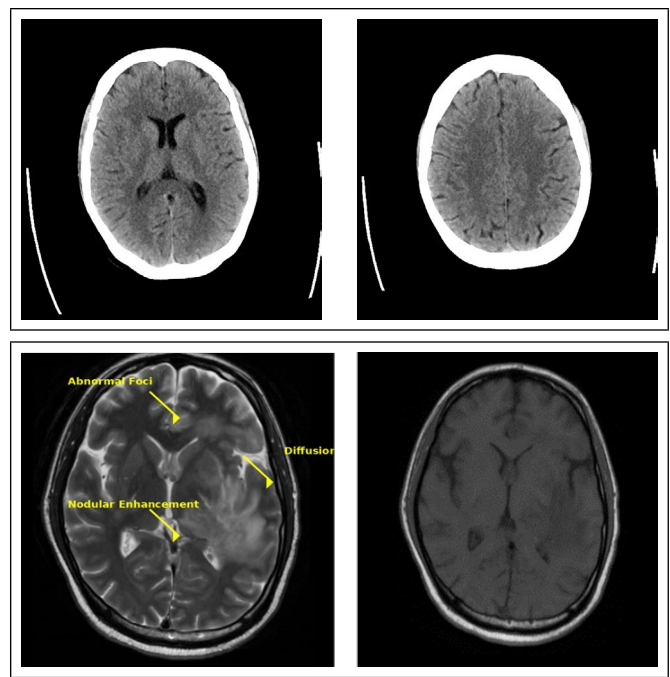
MRI of the left frontoparietal lobe and basal ganglia showing abnormal foci with diffusion restriction and nodular enhancement (highlighted with yellow arrows).
